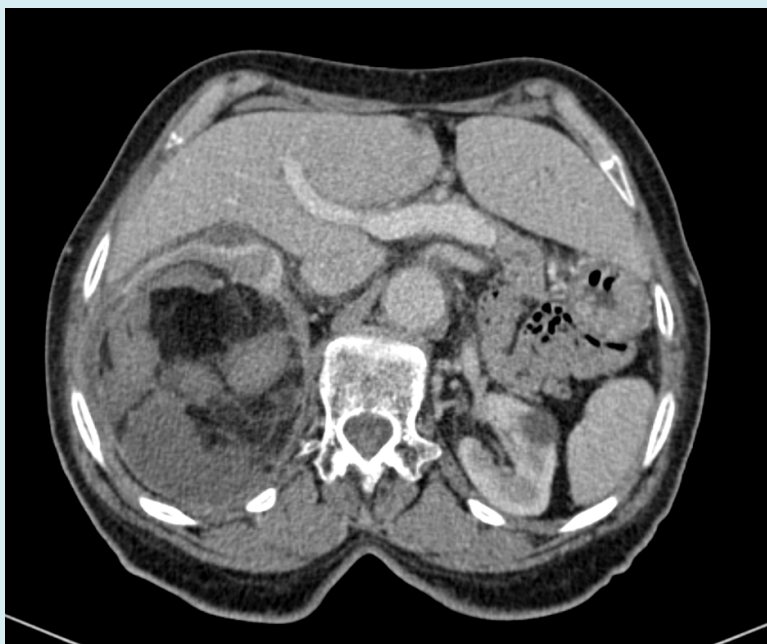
Abdominal-pelvic CT-Scan with PDC injection in axial section, clearly showing right renal angiomyolipoma complicated by hemorrhage.
